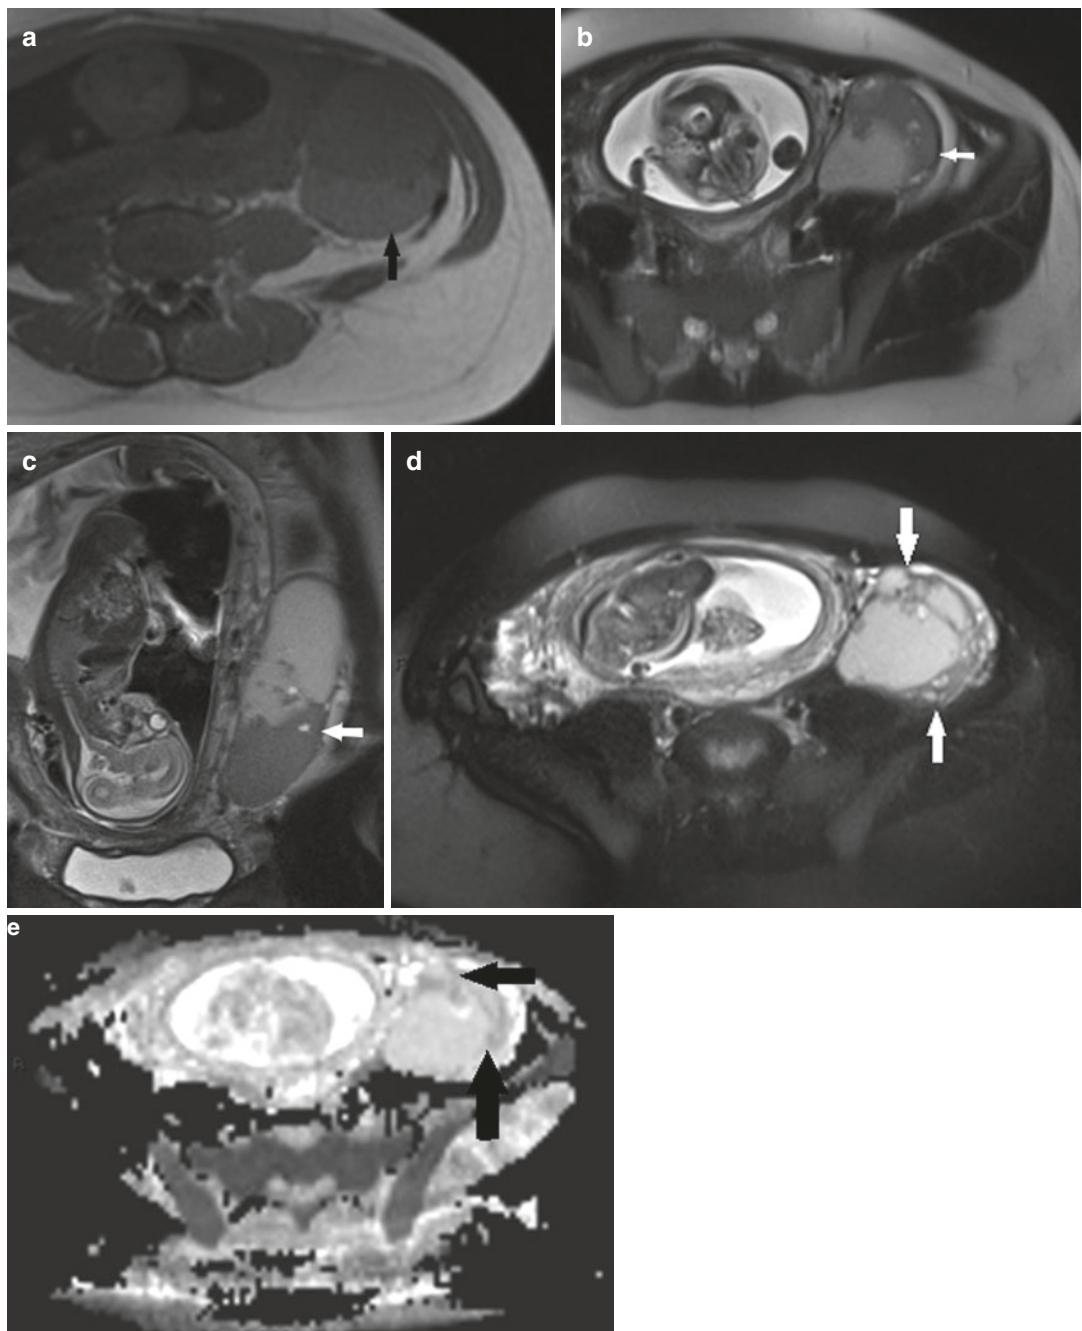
A 31-year-old woman at 29 weeks' gestation with acute left-sided pain. Axial T1 (a) and axial (b) and coronal (c) T2-weighted HASTE MR images show a complex mass, with fluid and solid components in the left ovary (arrow). Axial fat-suppressed T2-weighted MR
